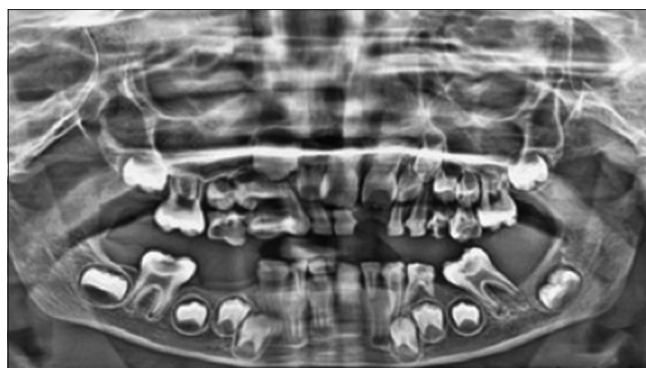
OPG-Orthopantomogram
